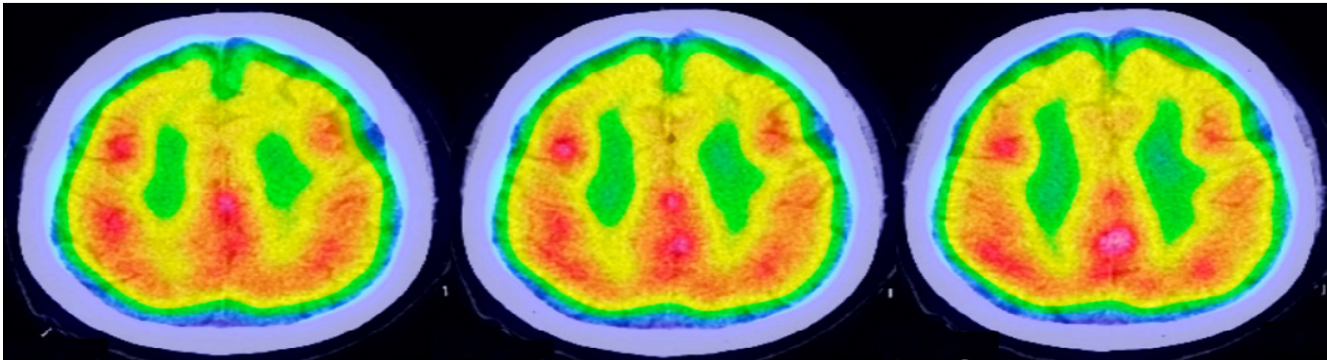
Transverse brain SPECT/CT taken in 2023, before initiating duloxetine
